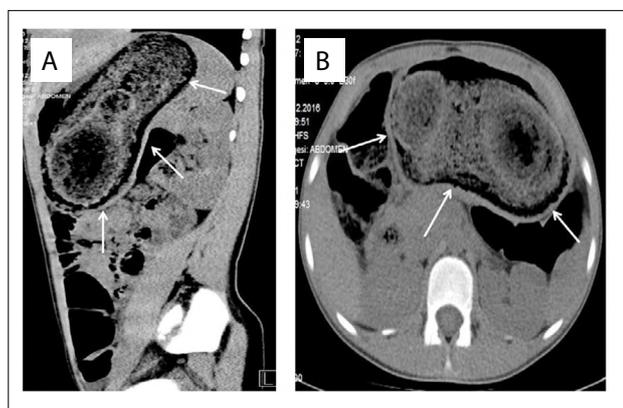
Computed tomography views: soft-tissue densities possibly compatible with a bezoar inside the stomach.
